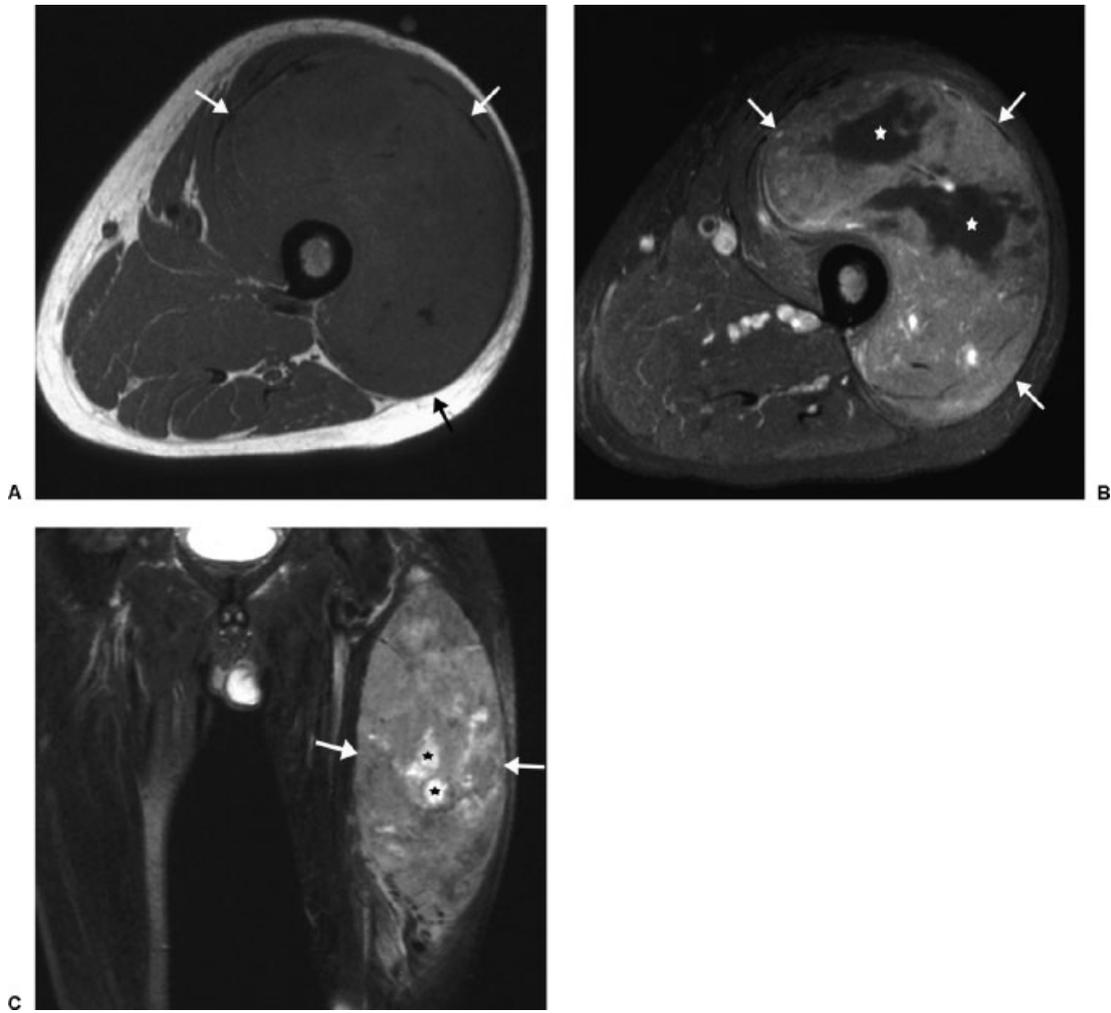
Pleomorphic malignant fibrous histiocytoma (undifferentiated high-grade pleomorphic sarcoma) in a 49-year-old man with a large thigh mass. (A, B) Axial T1-weighted (A, 500/20) and postcontrast fat-suppressed T1-weighted (B, 400/15) postcontrast with fat suppression MR images reveal a large intramuscular soft tissue mass (arrows) that is intermediate signal intensity on T1 weighting and has heterogeneous contrast enhancement with nonenhancing central areas of necrosis (asterisks). (C) Coronal fat-suppressed T2-weighted (4000/50) MR image reveals heterogeneous predominantly intermediate signal intensity soft tissue mass (arrows) with foci of high signal centrally corresponding to central necrosis (asterisks).
